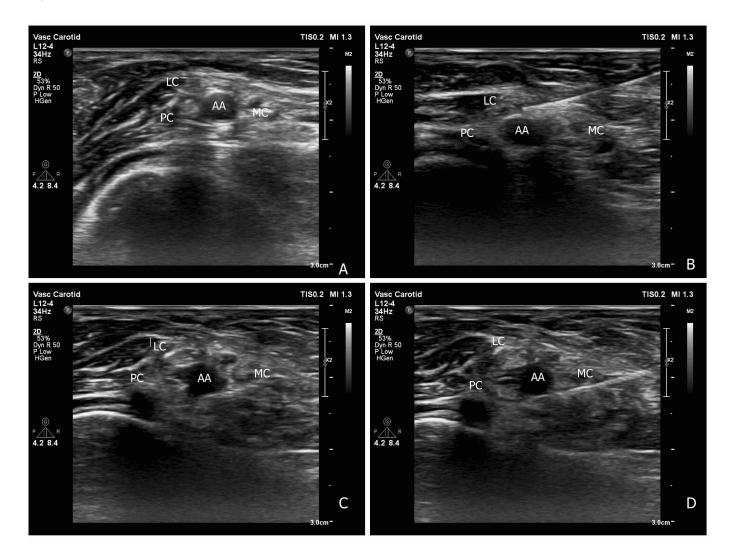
Ultrasound image of the proximal perivascular block. (A) Brachial plexus with three cords: the lateral cord (LC), medial cord (MDC), and posterior cord (PC). (B) Needle was inserted in the 12-o'clock direction of the axillary artery, and local anesthetic was injected. (C) Blurring of the axillary artery wall (Silhouette sign). (D) The needle was inserted in the 6-o'clock direction from the axillary artery.
